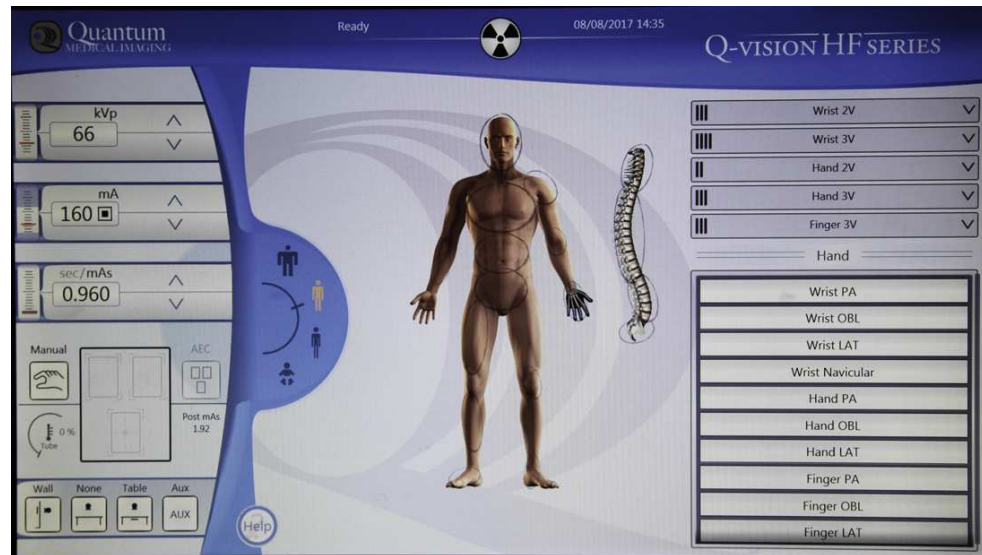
Anatomic programmer on x-ray generator. Technical exposure factors for most body parts are preprogrammed into the computer. The factors on this display are for a PA projection of the hand.
